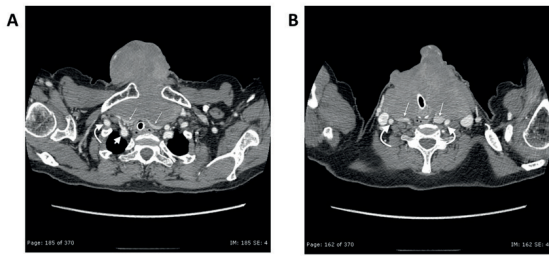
CT scan showed a large heterogeneous enhancing lobulated midline anterior neck mass protruding into subcutaneous fat tissue. The tumor also displaced both common carotid arteries (curved arrow) posteriorly and had pressure effect on thyroid gland (thin arrow). (short arrow-subclavian artery). (A) CT scan at superior mediastinal level; (B) CT scan at neck level.
